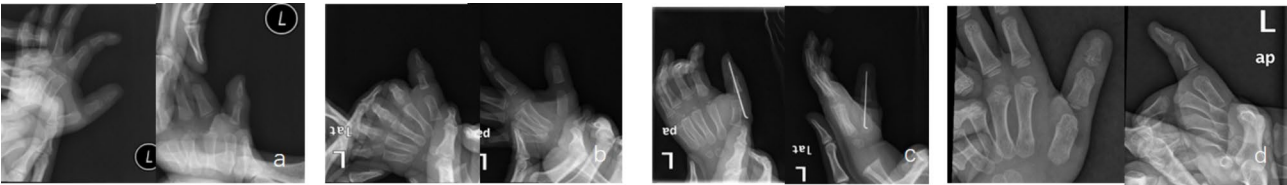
a. 25-month-old boy was initially confirmed as PNF with Type I fracture of the left thumb and underwent cast immobilization immediately in the emergency department. b however, radiographs at follow-up a week later showed a Type II fracture on the lateral view. c. closed reduction and a single k-wire fixation. d. satisfied radiologic outcome and function at 18 months after operation
